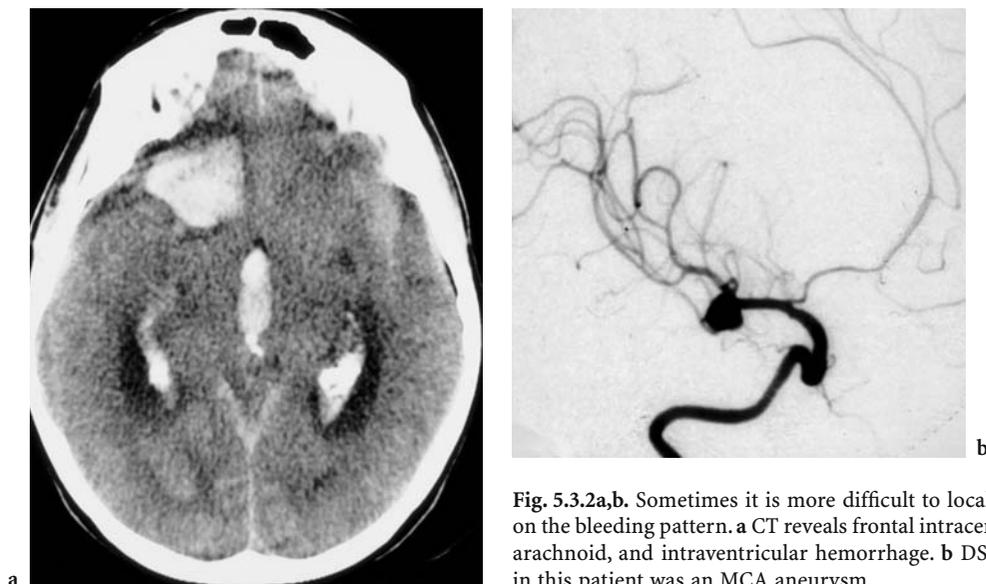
Sometimes it is more difficult to localize an aneurysm based on the bleeding pattern. a CT reveals frontal intracerebral hemorrhage, subarachnoid, and intraventricular hemorrhage. b DSA: The bleeding source in this patient was an MCA aneurysm
